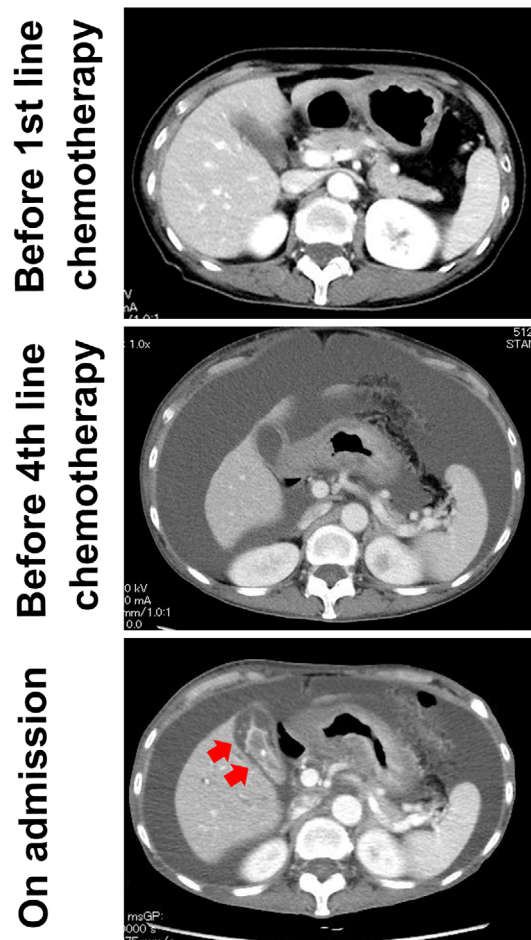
Diagnostic imaging of the liver. Contrast-enhanced computed tomography (CT) on admission showed diffuse intrahepatic cholestasis and normal-appearing parenchyma with no signs of malignant infiltration of the liver. Wall thickening of the gall bladder was apparent (arrows). Ascites was reduced on admission compared with before fourth-line chemotherapy.
